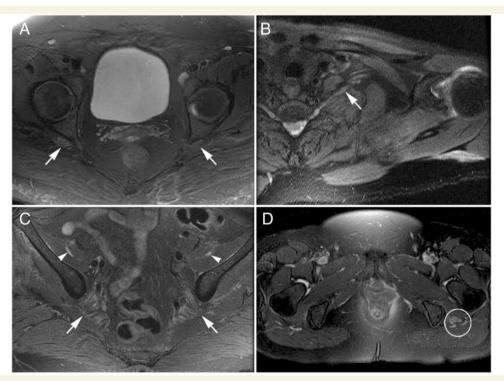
MRI characteristics of post-surgical inflammatory neuropathy. (A) T2 hyperintensity and mild enlargement of bilateral sciatic nerves, right more than left (arrows) (Case 3); (B) T₂ hyperintensity and mild enlargement of left C8 root and lower trunk (arrow) (Case 2); (C) T₂ hyperintensity and moderate enlargement of the bilateral femoral nerves (arrowheads) and mild enlargement of the sciatic nerves (arrows) (Case 21); (D) T₂ hyperintensity and severe enlargement of left sciatic nerve (circled) (Case 11).
